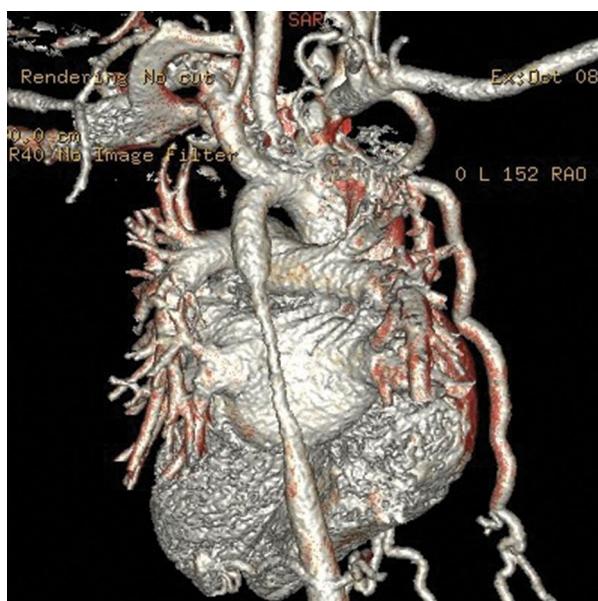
Computed tomography (CT) three-dimensional (3D) reconstruction – narrowing tubular (55 mm long) narrowed section of thoracic aorta (to 2.5 mm diameter) with concomitant collateral circulation
